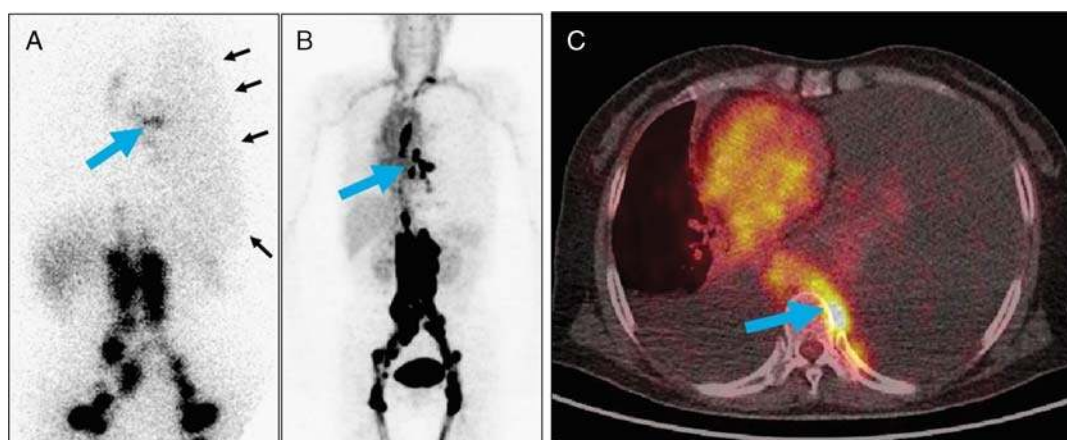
A 58-year-old woman (patient 8) presented with chest tightness for 8 months. Routine examination revealed pleural effusion in both sides of the thorax, more severe on the left side. Laboratory examination of thoracocentesis drainage confirmed chylothorax. $^{99\text{m}}\text{Tc}$ -SC scintigraphy (A) at 1 hour after injection showed relatively focal radioactivity (large arrow) in the left middle chest. In addition, mild, diffuse radioactivity (small arrows) in the entire left thorax was noted. The abnormal radioactivity distribution in the left mediastinal area is much more obvious on ^{68}Ga -MIP image (B) of NEB PET/CT acquired 15 minutes after tracer injection. Interestingly, the activity in the left pleural effusion was not as obvious on PET images as the $^{99\text{m}}\text{Tc}$ -SC image (compared with A). The PET/CT fusion image demonstrated that this activity (large arrow) was on the left of T7 vertebral body (C).
